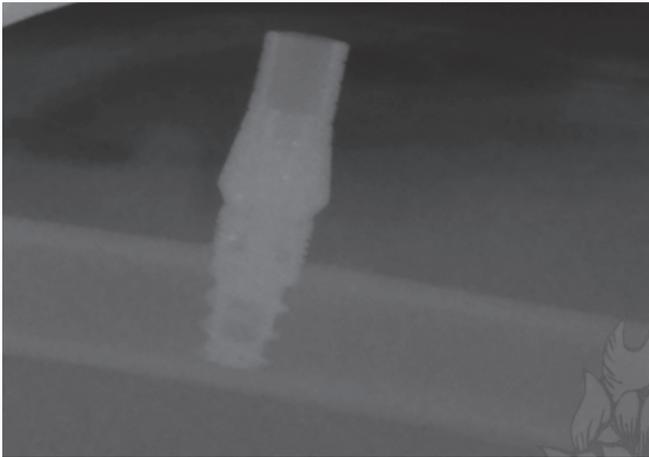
Radiograph showing implant with abutment
